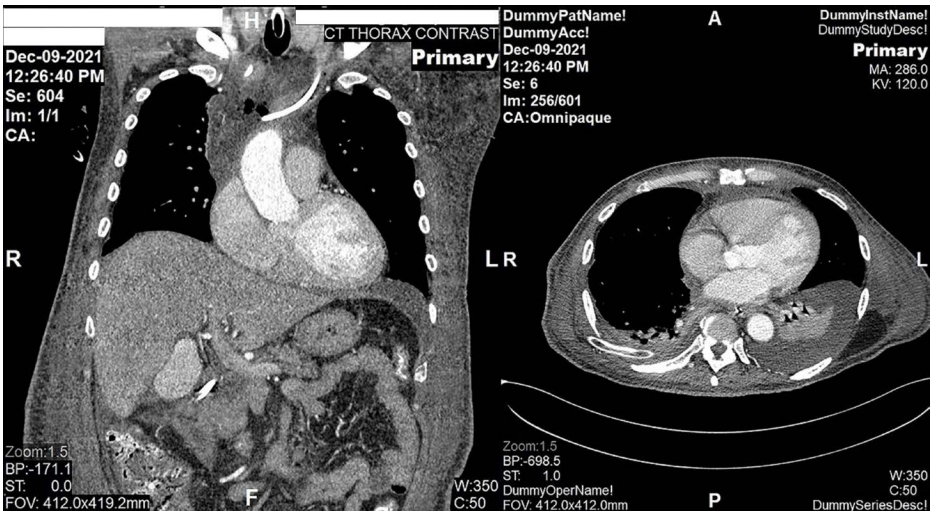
(Left) Computed tomography (CT) of the thorax (coronal view) showing anterior mediastinal haematoma with intervening air pockets. This collection measured approximately 3.9 x 8.7 x 13.1 cm (AP x W x CC). The distal tip of the left internal jugular catheter is seen to be extravascular and within the mediastinal haematoma. (Right) CT of the thorax (axial view) showing bilateral pleural effusion (moderate on the left and minimal on the right), with adjacent collapsed consolidation of the whole lower left lobe.
